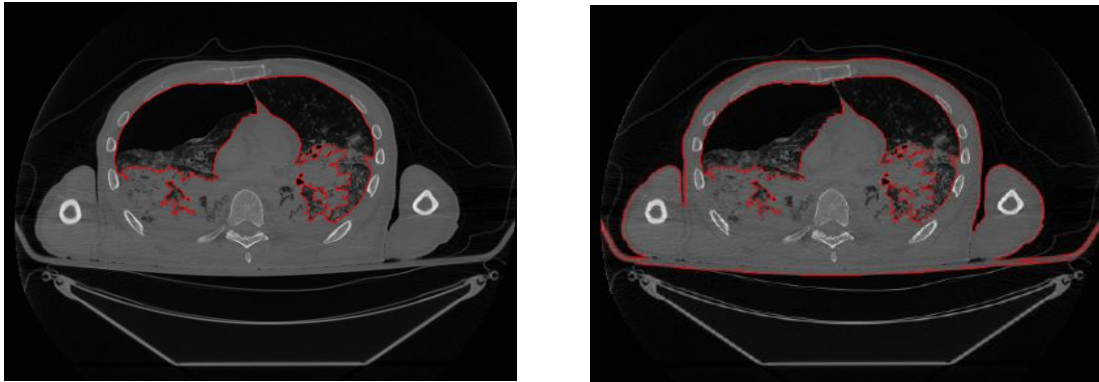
Initial torso (including arms and partial CT bed) segmentation of 8th thoracic vertebra in subject 00606M, using the global thresholding and morphological transformations.
